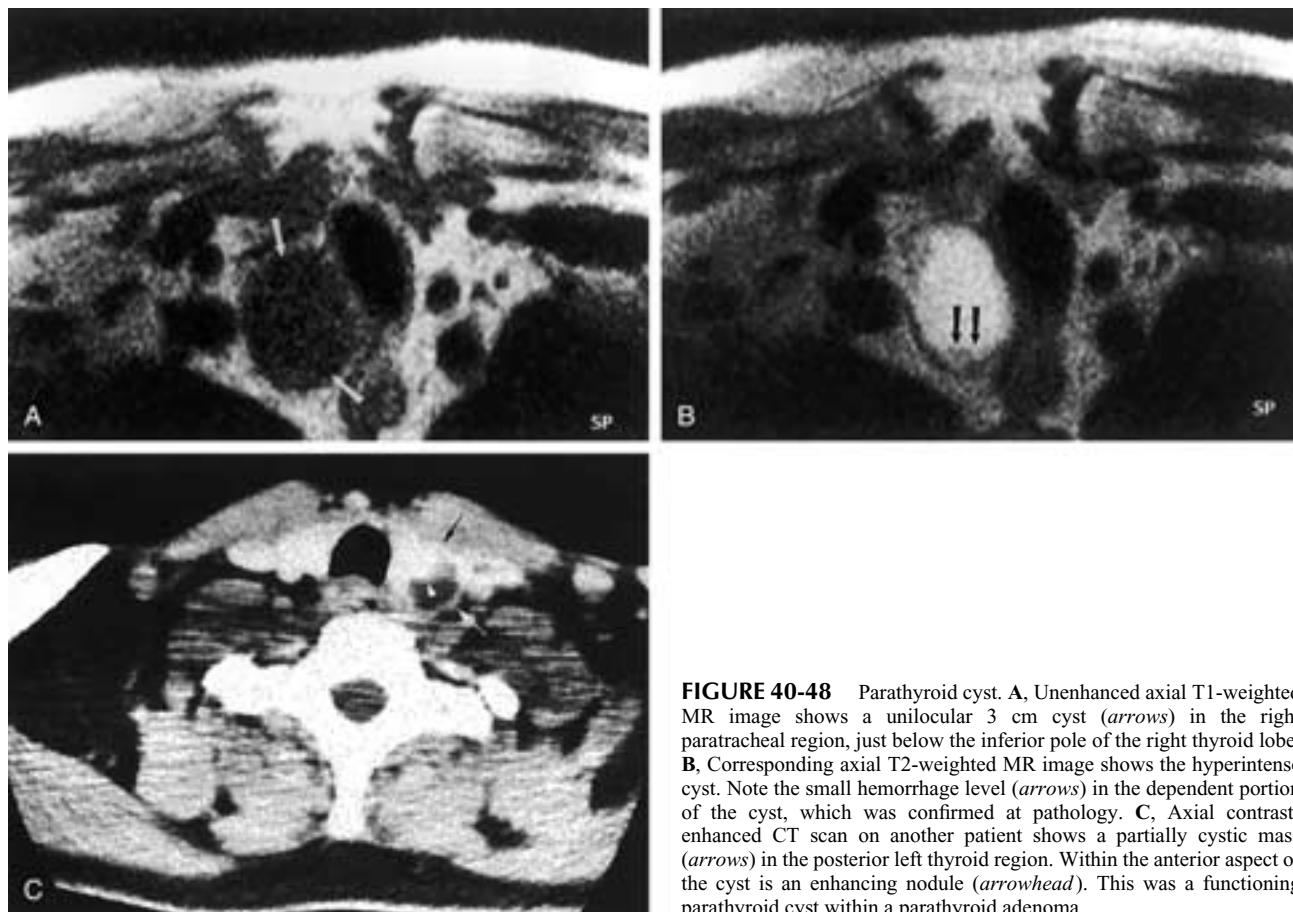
Parathyroid cyst. A, Unenhanced axial T1-weighted MR image shows a unilocular 3 cm cyst (*arrows*) in the right paratracheal region, just below the inferior pole of the right thyroid lobe. B, Corresponding axial T2-weighted MR image shows the hyperintense cyst. Note the small hemorrhage level (*arrows*) in the dependent portion of the cyst, which was confirmed at pathology. C, Axial contrast-enhanced CT scan on another patient shows a partially cystic mass (*arrows*) in the posterior left thyroid region. Within the anterior aspect of the cyst is an enhancing nodule (*arrowhead*). This was a functioning parathyroid cyst within a parathyroid adenoma.
